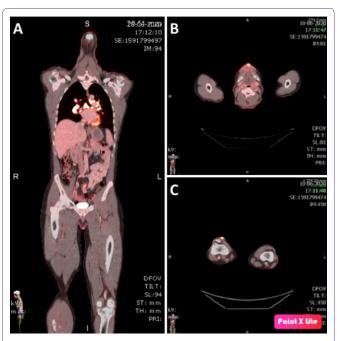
PET-CT imaging. A) Full body overview with multiple hypermetabolic foci, most pronounced at the level of mediastinal and hilar lymph nodes. B) Hypermetabolic foci right prepatellar. C) Hypermetabolic foci at the upper lip.
